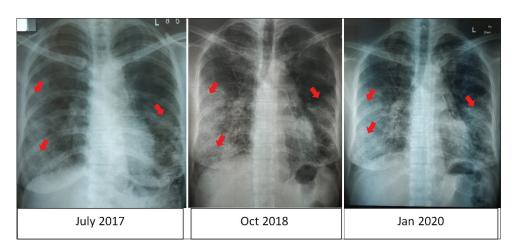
The serial chest X-ray showed bilateral symmetrical consolidation (red arrows) with predominance in the peripheral, perihilar, and basal area.
